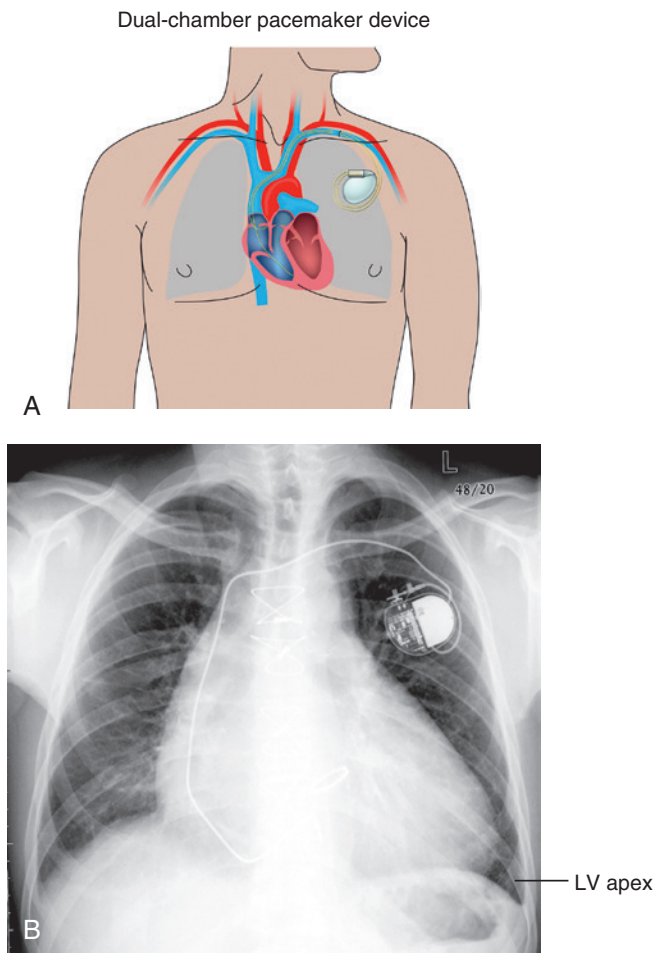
A, The site of implantation of a permanent pacemaker (note: can be inserted in the left or right intraclavicular chest wall). B, A chest radiograph showing a pacemaker in a patient. LV, Left ventricular. (A, Courtesy of Matt Hazzard, University of Kentucky. B, From Bonow RO, et al, editors: *Braunwald's heart disease: a textbook of cardiovascular medicine*, ed 9, Philadelphia, 2012, Saunders.)
